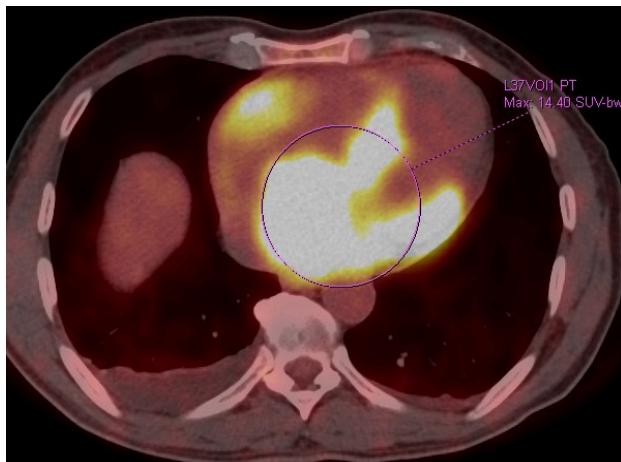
F-18 FDG PET/CT demonstrating intense radiotracer uptake localized to the right and left atrial regions of the heart.
